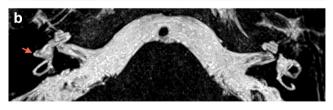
a: magnetic resonance imaging, axial section, T2HR 3D sequence with MIP reconstruction; the red arrow indicates lateral semicircular canal aplasia with no associated cochlear or vestibular abnormality; b: magnetic resonance imaging, axial section, T2HR sequence; the red arrow indicates lateral semicircular canal aplasia.
